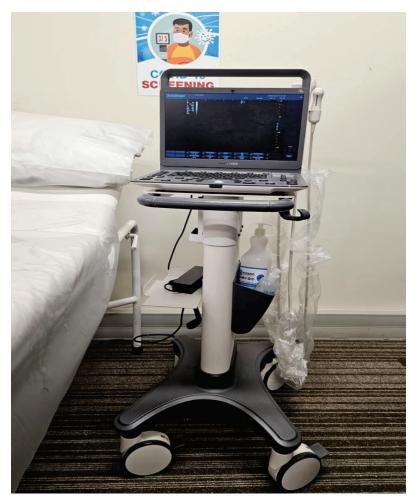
Echocardiography system⁴
